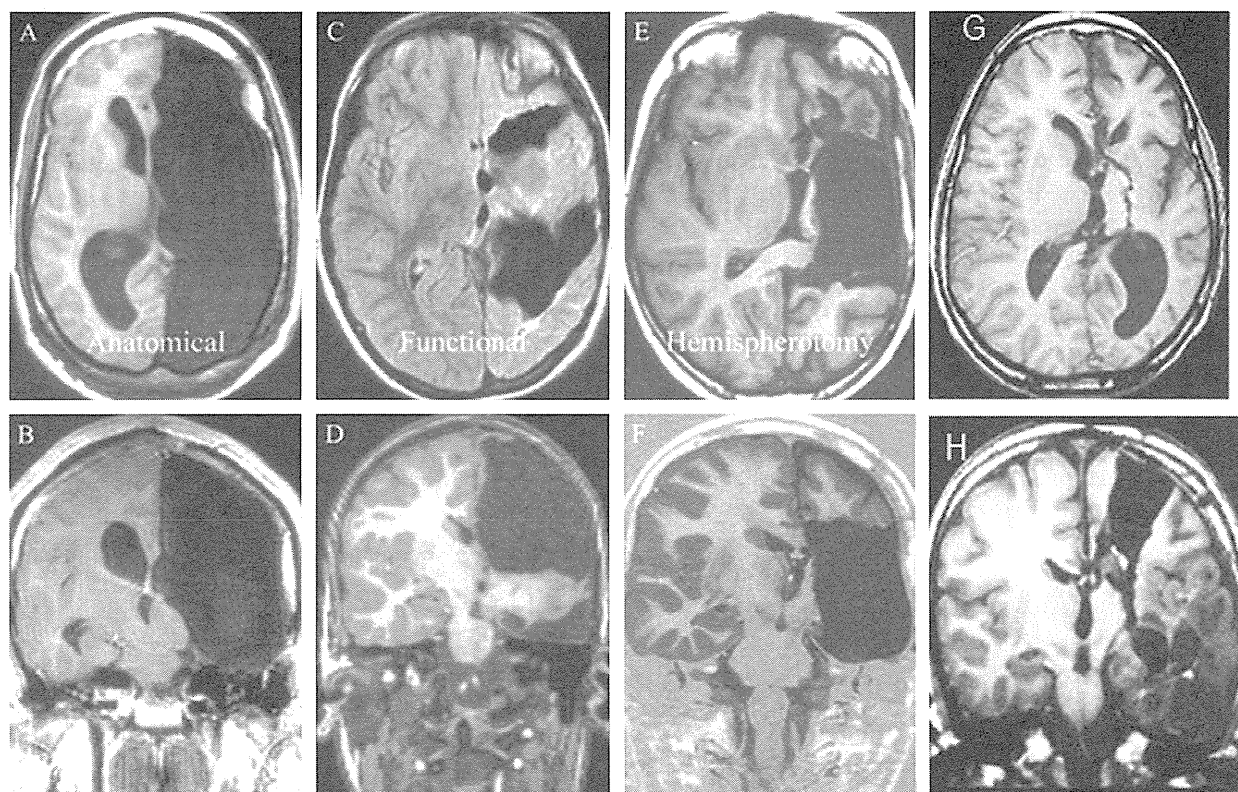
Axial (upper) and coronal (lower) MRI scans demonstrating the main surgical procedure for hemispheric disconnection; (A–F) belong to Cook et al. (2004), (G) and (H) belong to Delalande et al. (2007). (A and B): Anatomical hemispherectomy produced by removal of the entire hemisphere including most of the deep structures of the basal ganglia, thalamus, and caudate nucleus. (C and D): Rasmussen functional hemispherectomy based on a combination of partial anatomic excision (insular cortex and basal ganglia are not resected) and disconnection of the remaining lobes. *To further decrease complication rates after hemispherectomy, new surgical procedures have been developed that reduce the volume of brain removal and increase the ratio of disconnection to resection and was called hemispherotomy.* (E and F): modified lateral or peri-insular hemispherotomy removes a block of tissue that includes the fronto-temporo-parietal operculum and underlying deep structures. (G and H): vertical parasagittal hemispherotomy the incision around the central core (consists of the extreme, external, and internal capsules, claustrum, lentiform and caudate nuclei, and thalamus) respecting the same section as in anatomic hemispherectomy with preservation of an intact vessel supply.
